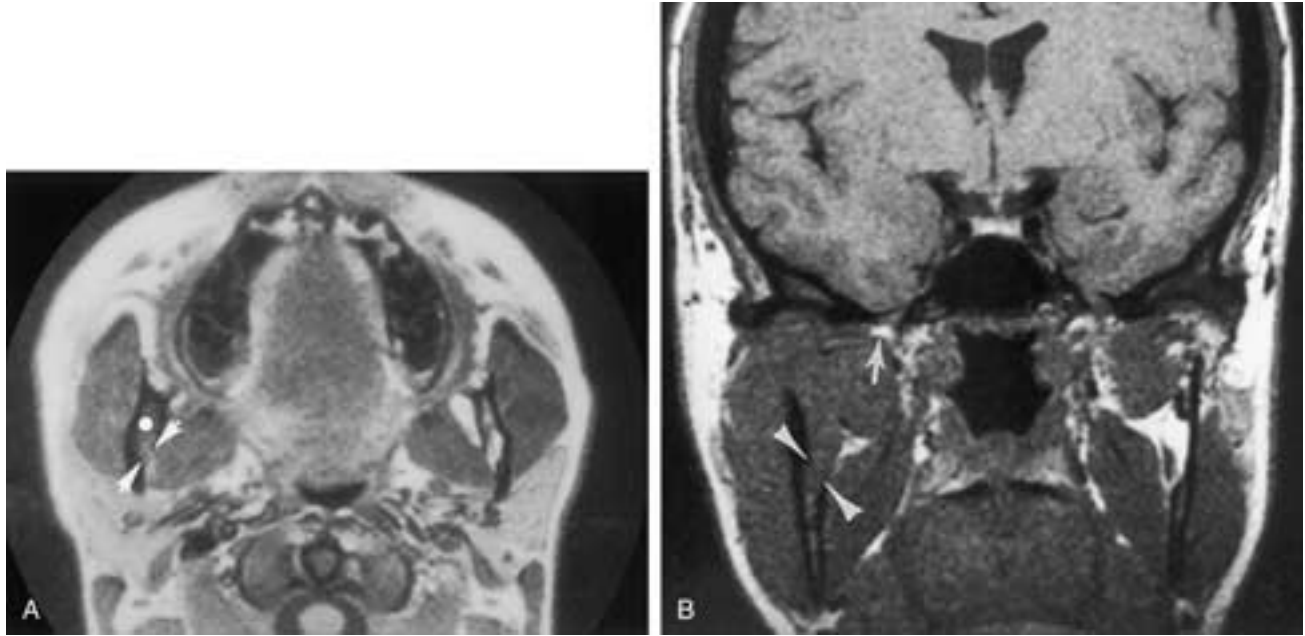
Mandibular chondrosarcoma. A and B, Axial and coronal T1-weighted MR images demonstrate a right masticator space mass with involvement of the lateral pterygoid, medial pterygoid, and masseter muscles. There is antegrade perineural tumor extension along the inferior alveolar nerve with widening of the inferior alveolar foramen (*white arrowheads*). Replacement of the normal high signal fatty marrow is best appreciated on the axial image (*white dot*). At this time, there is no evidence of retrograde perineural tumor because the margins of the right foramen ovale are intact and normal fat is identified just inferior to the foramen (*white arrow* in B). (From Tryhus MR, Smoker WRK, Harnsberger HR. The normal and diseased masticator space. *Semin Ultrasound CT MR* 1990;11:476–485.)
